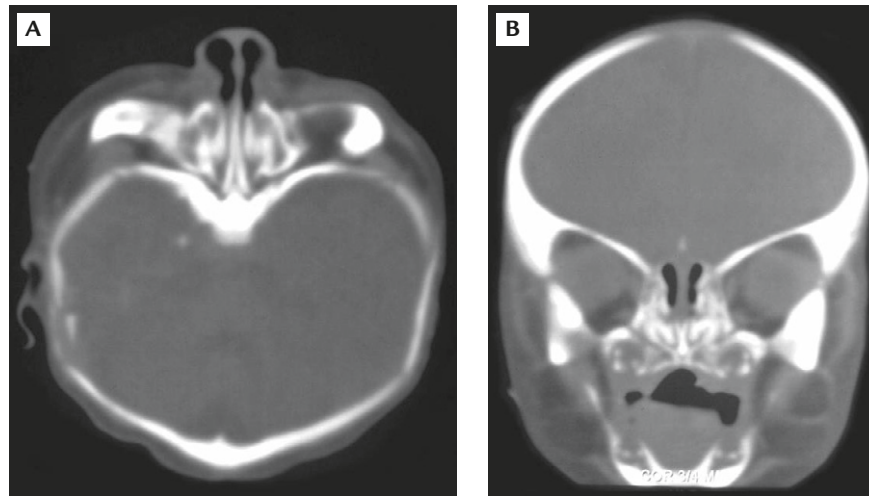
(A) Axial and (B) coronal computed tomography scans of the nose and the paranasal sinuses showing symmetric narrowing of both nasal cavities.
